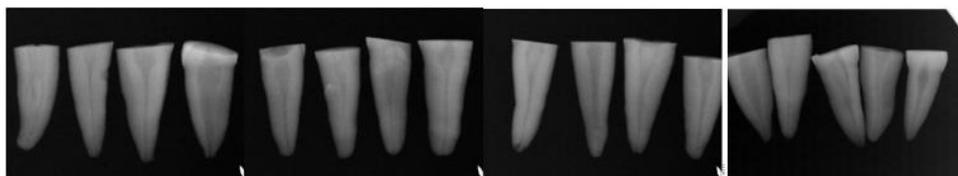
X-ray of decoronated samples.
